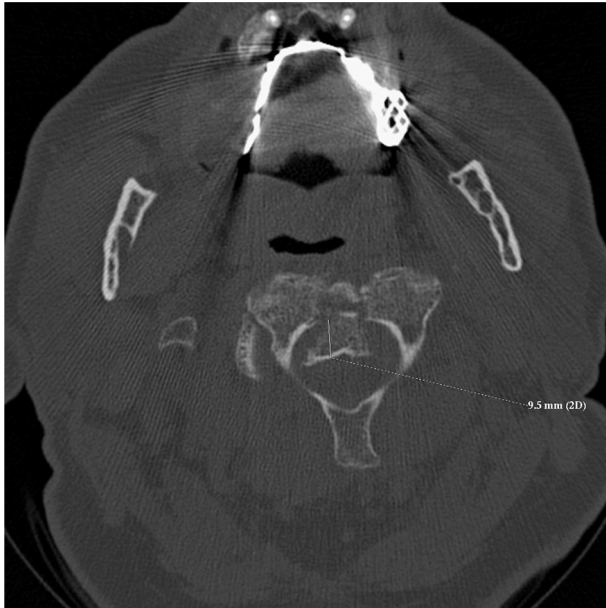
Axial computed tomography scan shows fracture of the base of the odontoid with posterior displacement.
